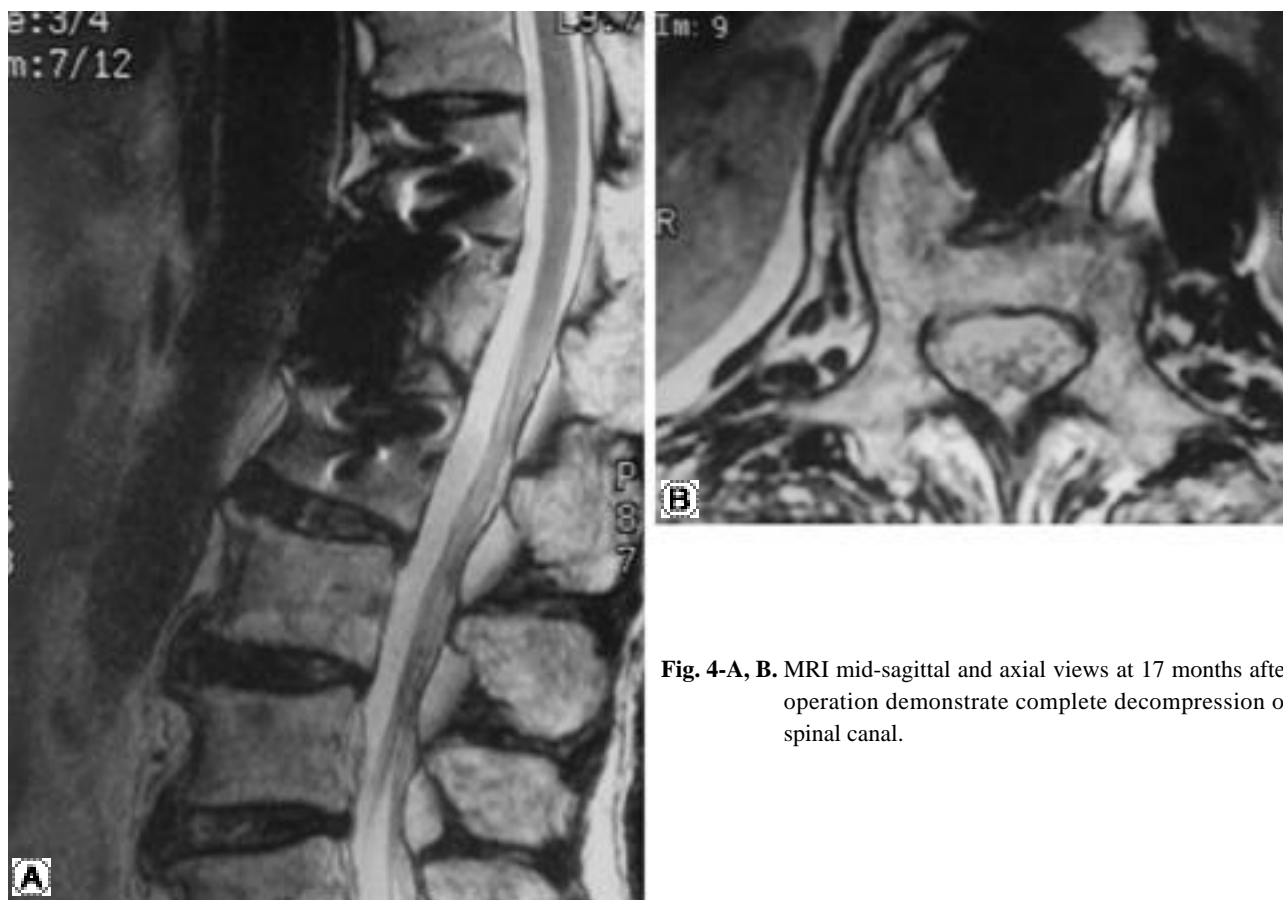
MRI mid-sagittal and axial views at 17 months after operation demonstrate complete decompression of spinal canal.
